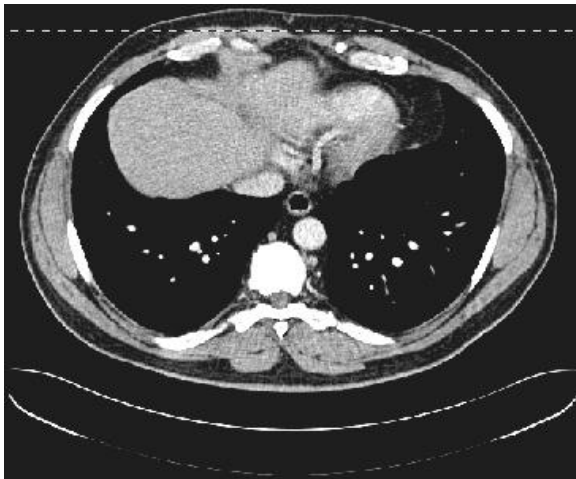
Slice No. 36 of 237 CT slices from XZ direction through holding slice No. 18 in XY direction
